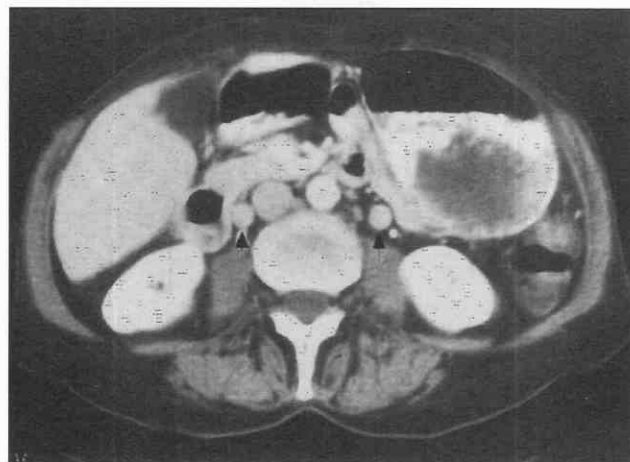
Prominent gonadal veins (arrows) are visualized on this dynamically enhanced CT scan. They should not be confused with enlarged retroperitoneal lymph nodes.
